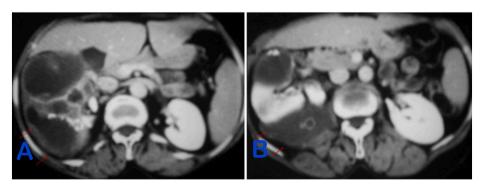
Computed tomography: Right renal calcified multicystic mass (A) Cystic mass of the right psoas (B).
